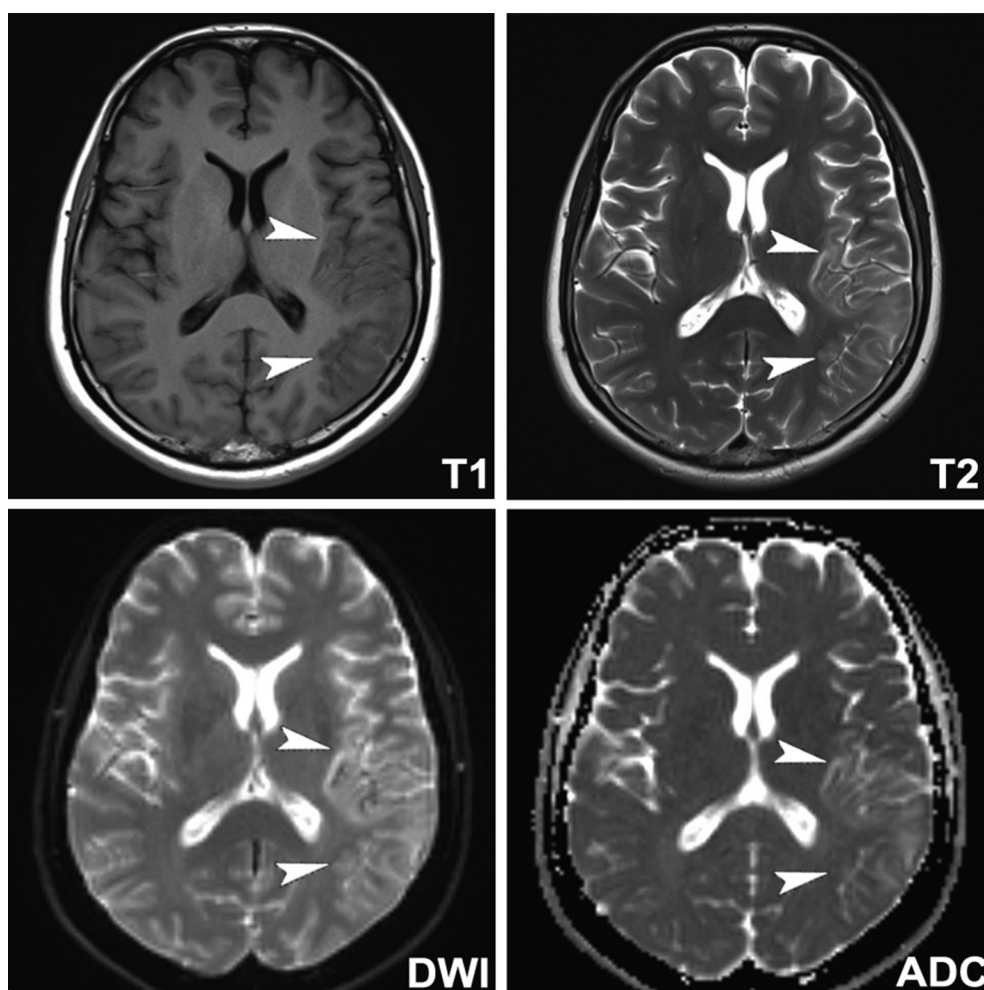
MRI of brain showed increased T1/T2 and diffusion weighted imaging/apparent diffusion coefficient signal in the left cerebral hemisphere (arrowheads). ADC = apparent diffusion coefficient; DWI = diffusion weighted imaging.
